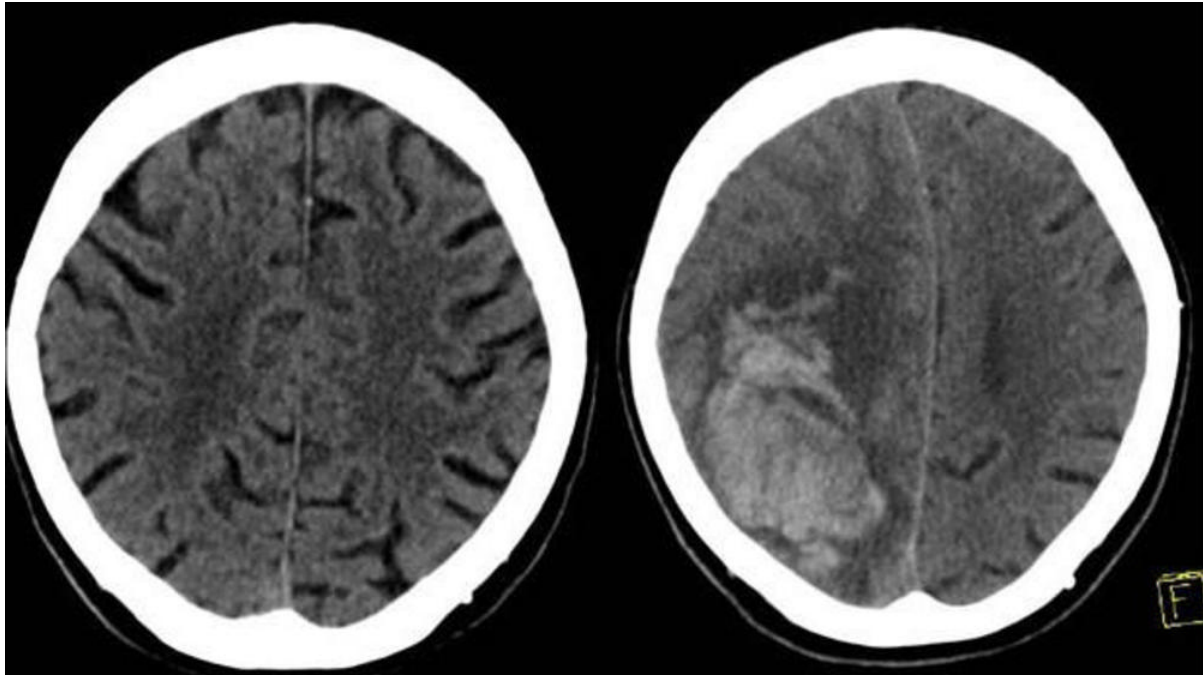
The left image shows the initial CT scan of the brain in a patient on both clopidogrel (Plavix) and aspirin who presented to the Emergency Department with head trauma that did not demonstrate any intracranial hemorrhage. The right image shows a head CT obtained 24 hours later demonstrating a large parenchymal hemorrhage in the right frontal/parietal region. The patient died shortly after the second examination.
